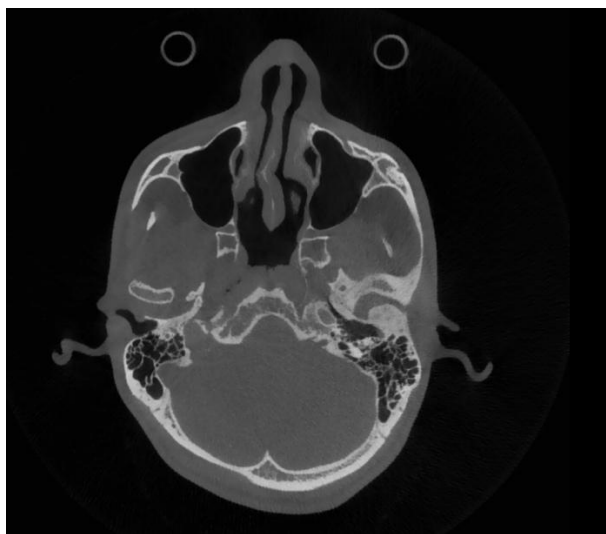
Post-operative axial CT section (bone window) demonstrating absence of the left condylar head following condylectomy, with a clearly defined arthroplasty gap and no evidence of bony bridging or re-ankylosis. Right TMJ is preserved (normal internal reference).
